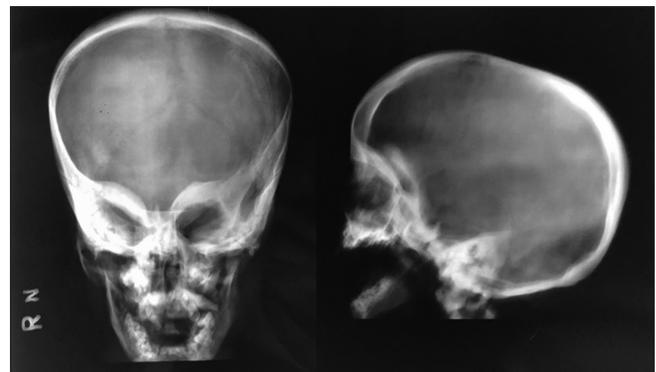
Anteroposterior and lateral radiographs of skull confirm thickening and sclerosis of the skull base.
